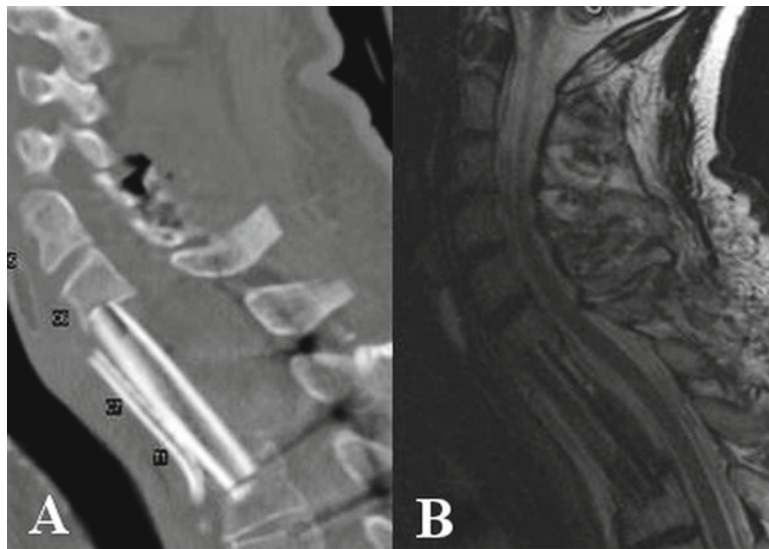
(a) Postoperative reconstructed sagittal CT scan of the same patient shows appropriate placement of a strut graft at the corpectomy site. (b) Sagittal T2WI confirms spinal cord decompression. The restoration of the height and the reversal of the segmental kyphosis were achieved through a modified anterior cervical approach
